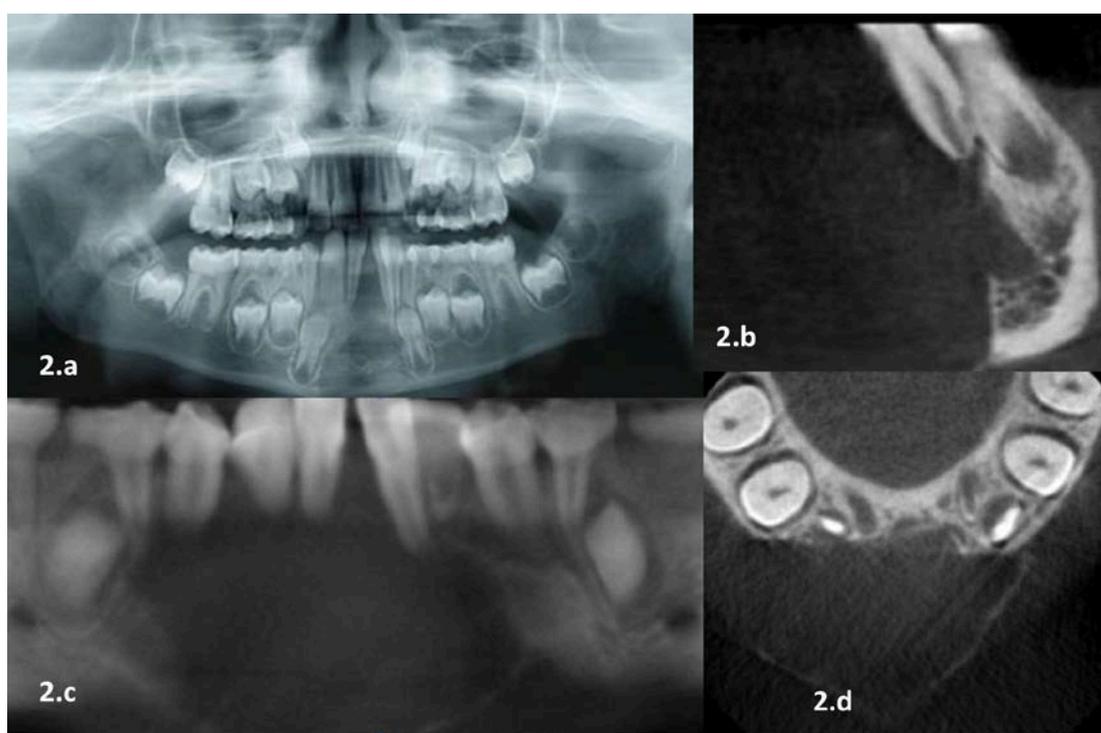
Radiographic appearance of the lesion 2.a: OPG showing diffuse radiolucency in the anterior region of mandible; 2.b, 2.c and 2.d: Lesion in various sections of CBCT
